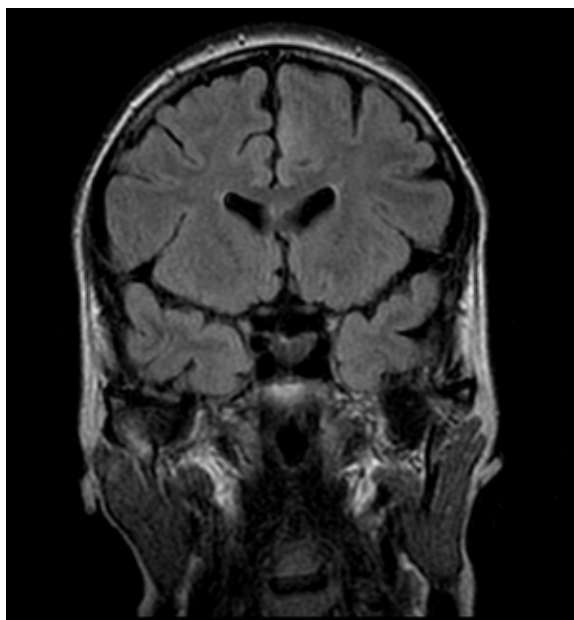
Cortical dysplasia in the left frontal lobe in a pregnant woman (week 28 of gestation) with a history of epileptic seizures who had not undergone MRI before. The seizures were exacerbated during pregnancy. The direct reason for MRI was a grand-mal seizure.
